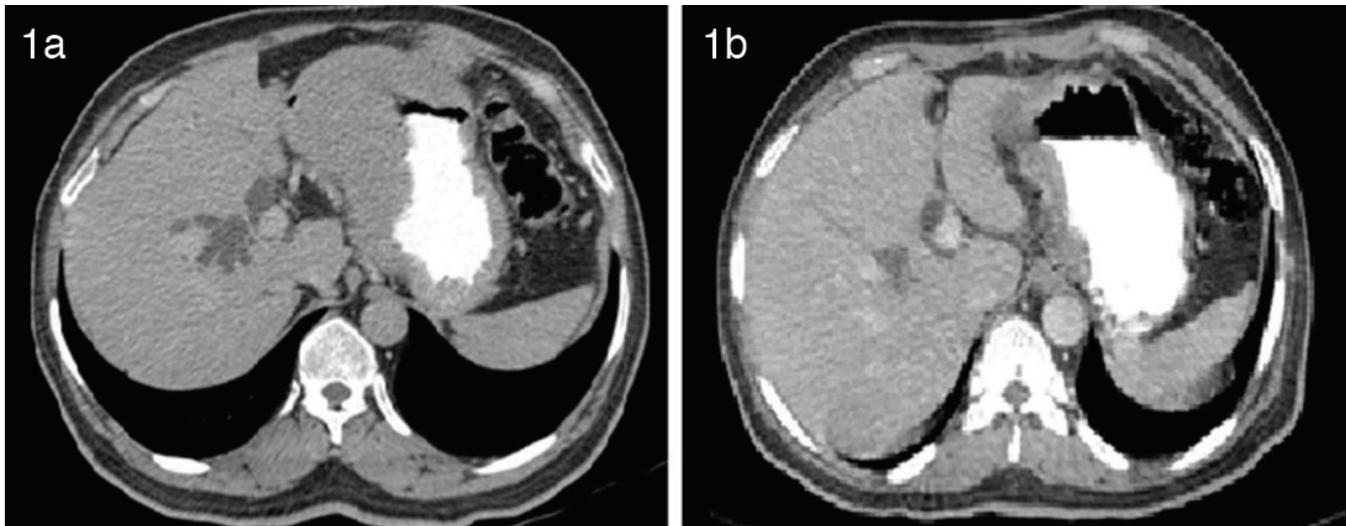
Contrast-enhanced computed tomography of the neck, chest, and abdomen showing intrahepatic biliary radicle dilatation and stomach wall thickening involving the cardia and lesser curvature of the stomach (a) and post-induction scan showing significant reduction in the stomach wall thickening and resolution of intrahepatic biliary radicle dilatation (b).
